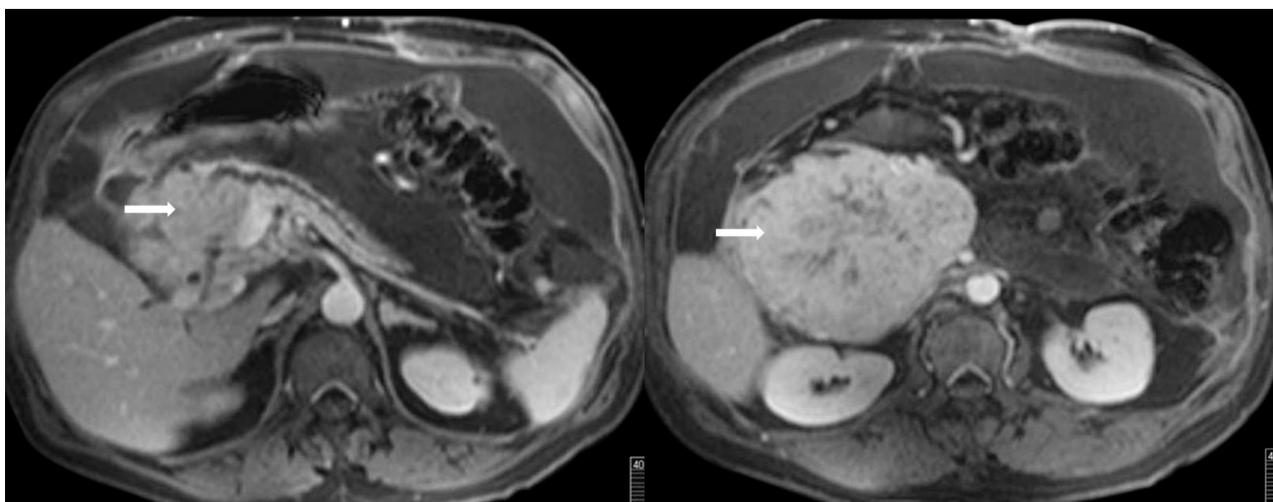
A, B. Contrast-enhanced fat-saturated T1-weighted transverse MR images show a massive, lobulated lesion with regular borders measuring 15x11x10 cm, in the head of pancreas (white arrows). There are no findings of invasion to the surrounding tissues, but it forms a distortion over the vascular structures.
